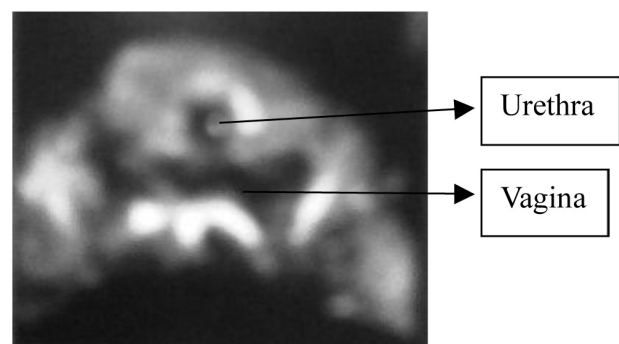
3D Perineal ultrasound showing loss of antero-lateral vaginal sulci-indicating bilateral paravaginal defect.
